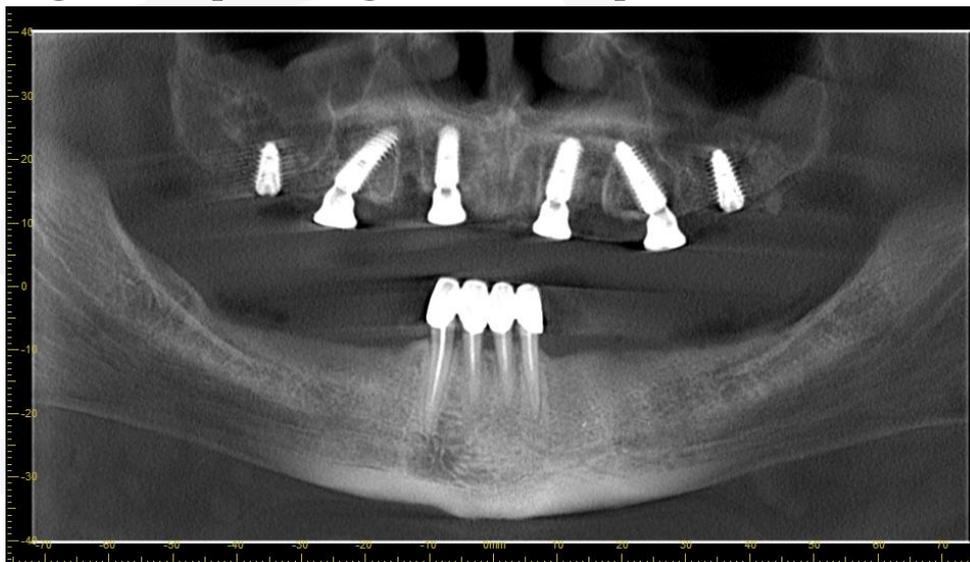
Orthopantomogram after installation of implants and gum formers
